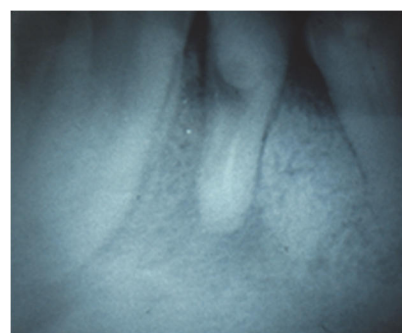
Target X-ray image of tooth 44 in the patient. The condition of the tooth within 12 months after treatment.
